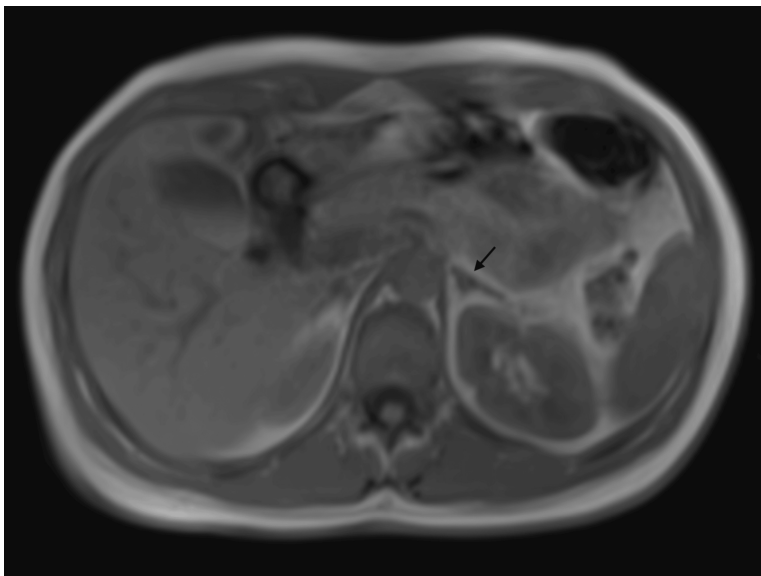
Abdominal magnetic resonance imaging showing a 1-cm aldosterone-producing left adrenal adenoma. T1-weighted magnetic resonance imaging showing a well-defined, 1-cm left adrenal nodule (arrow).
